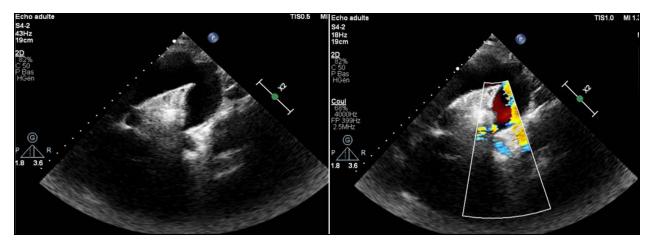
Transthoracic echocardiography suprasternal view 2D color. Aortic arch and descending aorta with turbulent flow across the stenotic postductal region and a poststenotic dilatation associated with elongation and kinking of the proximal segment of the descending aorta
